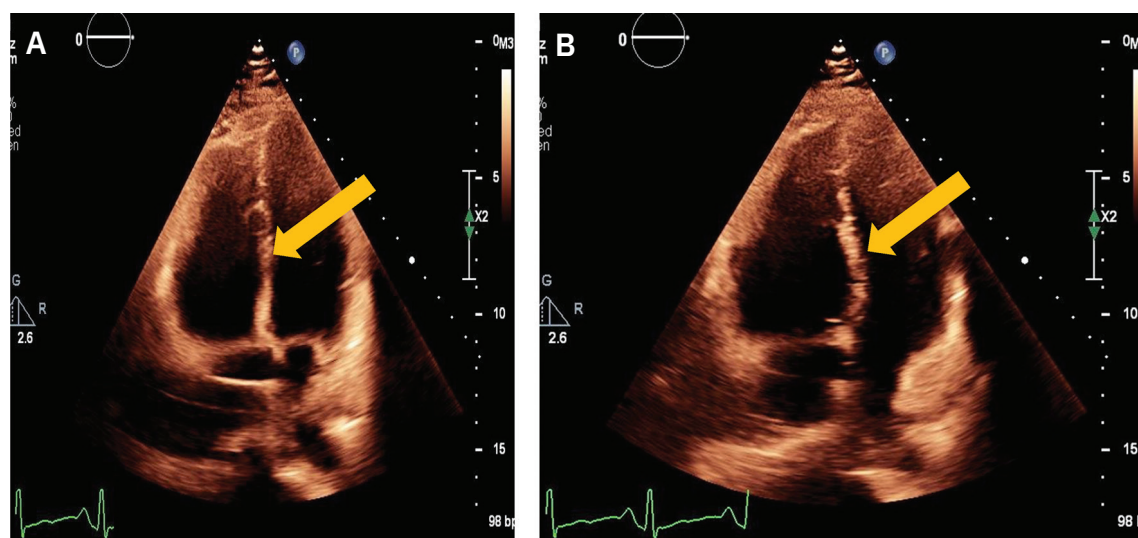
Right heart strain demonstrated by 2 transthoracic echocardiography (TTE) images.
